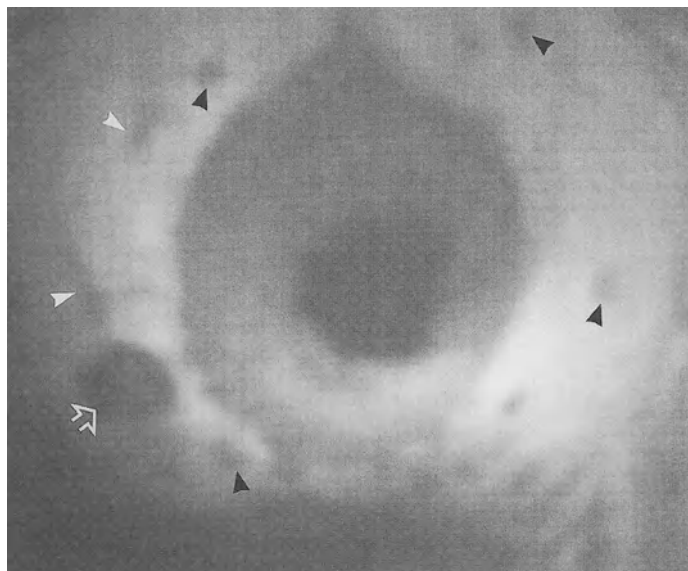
Axial T1-weighted SE image (TR/TE = 700/15) of the rectum of a patient with stage-T4 rectal cancer. Four small perirectal lymph nodes, 3 and 2mm in diameter (*black arrowheads*), are detected in the fatty tissue. In addition, one large perirectal lymph node >1 cm in diameter (*open white arrow*) is demonstrated (stage N2); *white arrowheads* indicate vessels
